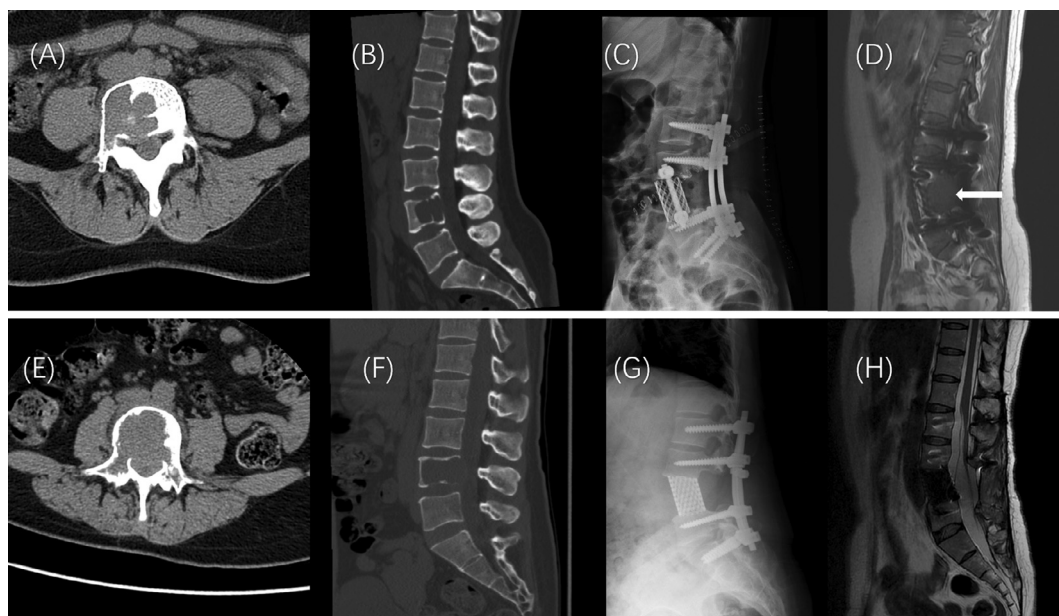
Two case examples. Top panel: A 39-year-old woman, (A-B) axial and sagittal CT images showing the lesion, (C) treated with total *en bloc* spondylectomy, and postoperatively confirmed as GCTB. (D) The sagittal T2-weighted MR image at 13-month follow-up, showing the progression of the residual tumor (arrow), and confirmed by pathology with puncture biopsy. The recurrence probability predicted by the radiomics model is 0.94, a true positive case. Bottom panel: A 34-year-old woman, (E-F) axial and sagittal CT images showing a mass on the L4 vertebra, (G) treated with total *en bloc* spondylectomy, postoperatively confirmed as GCTB. (H) At a 60-month follow-up MRI, there is no sign of recurrence. The patient is continuously being followed and showing no evidence of recurrence. The recurrence probability predicted by the radiomics model is 0.30, a true negative case.
